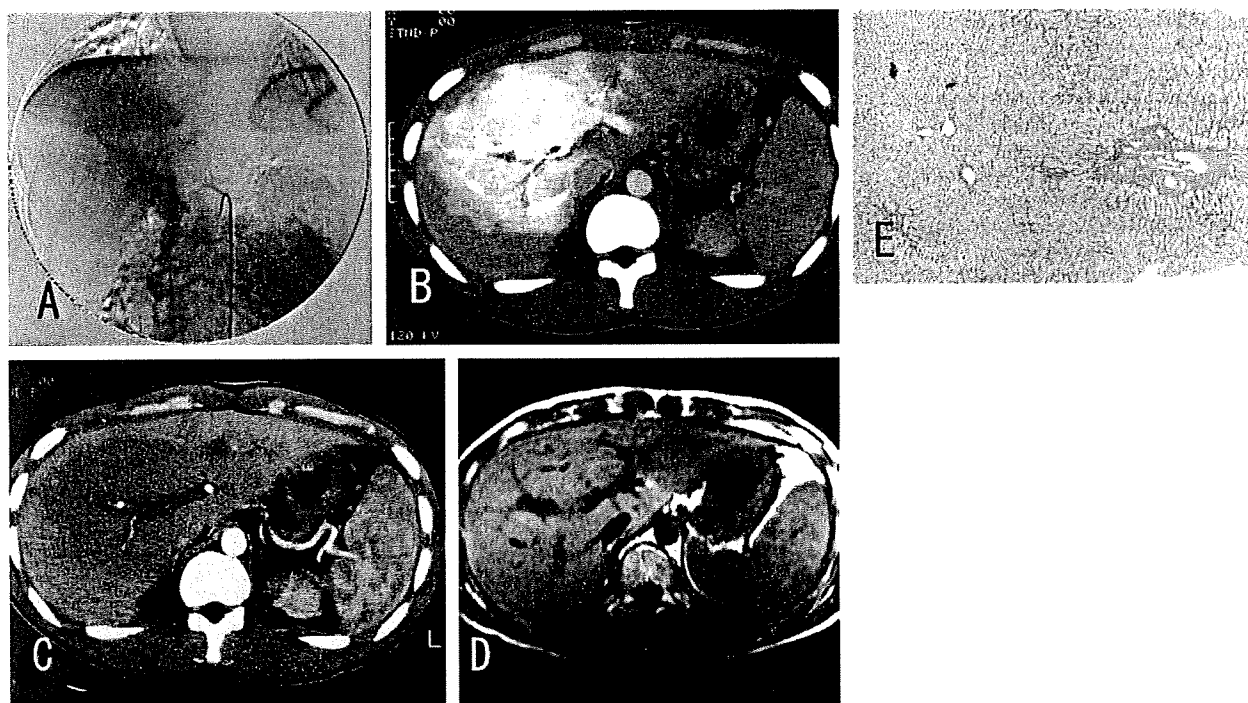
Central hypertrophy of the liver in a patient with portal vein thrombosis. A Portal phase image from superior mesenteric arteriography in a patient with portal vein thrombosis. The extra-hepatic portal vein is not opacified clearly, and collateral veins (i.e., cavernous transformation) are observed. B On CTAP, portal flow is shown to be preserved around the larger portal vein in the hilar area, and the peripheral liver shows portal flow defects. C Early arterial phase contrast-enhanced CT scan shows peripheral enhancement, and the perihilar area appears hypodense. D On
